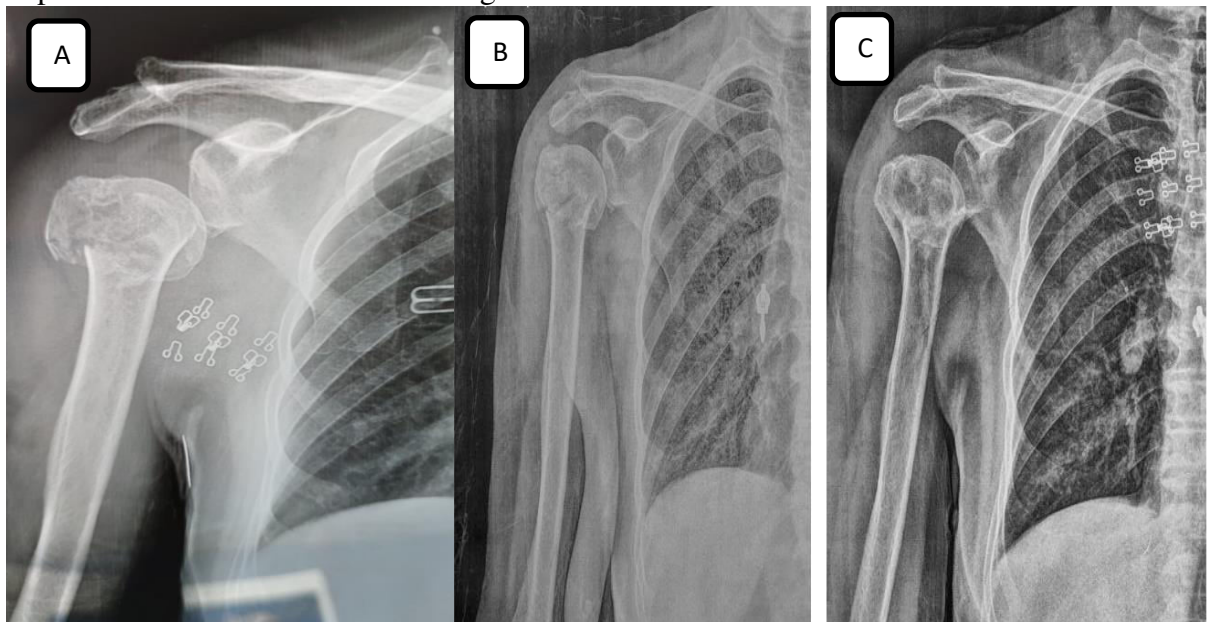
A: plain x-ray at time of trauma, B: follow up 1 month, C: follow up 6 months for a case treated by the conservative approach with closed reduction.
